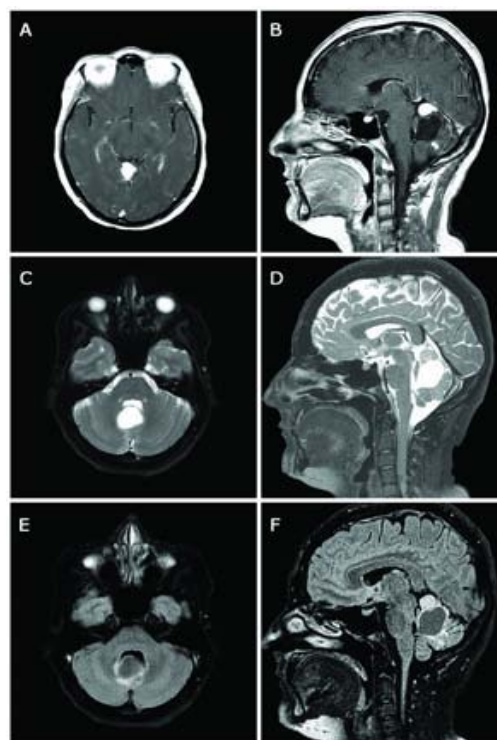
Magnetic resonance imaging of the brain showing solid/cystic cerebellar vermis lesion with gadolinium enhancement and compression of the fourth ventricle (A - Axial T1 with gadolinium enhancement, B - Sagittal T1 with gadolinium enhancement, C - axial in T2; D - sagittal in T2; E - axial FLAIR and F - sagittal FLAIR). The entire solid/cystic structure had approximate dimensions of 4.6 X 3.0 X 2.7 cm.
